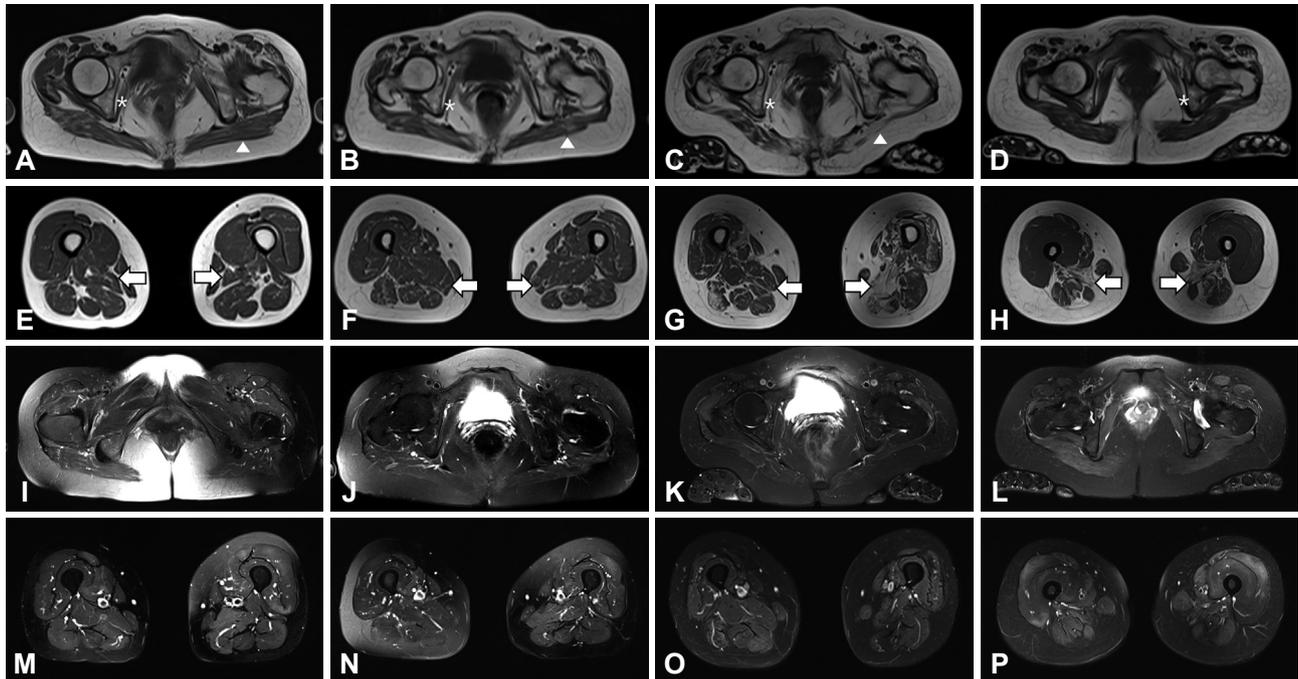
Lower-limb muscle MRI of two patients with anti-HMGCR myopathy: patients P7 (A-C, E-G, I-K, and M-O) and P16 (D, H, L, and P). A-P: Two patients were misdiagnosed as having muscular dystrophy due to slowly progressing muscle weakness and did not receive appropriate treatment for nearly 9 years after symptom onset. MRI was performed at 40 months (A, E, I, and M), 54 months (B, F, J, and N), and 109 months (C, G, K, and O) after symptom onset in patient P7 (A-C). At the hip level, T1-weighted images indicated predominant fatty replacement of the obturator (asterisk, A-D) and gluteus maximus (arrowhead, A-C) muscles over time. At the thigh level, T1-weighted images indicated asymmetric fatty replacement of adductors (arrows, E-G), long head of the biceps femoris, and semimembranosus muscles over time. T1-weighted images also presented predominant fatty replacement of adductors in P16 (arrows, H). Short tau inversion recovery signal increases were patchy and asymmetric (I-P). MRI, magnetic resonance imaging.
